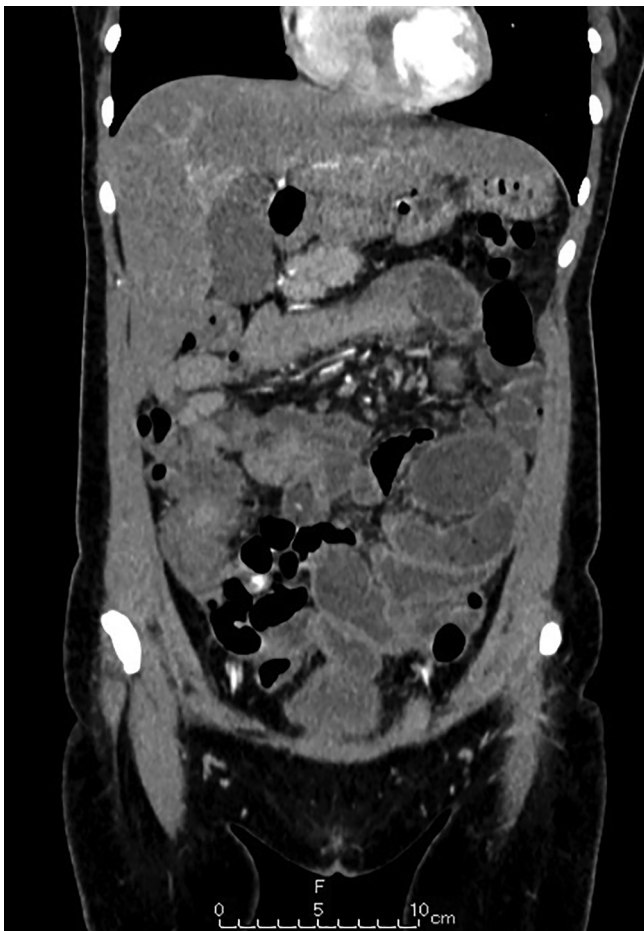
Contrast-enhanced CT, the peritoneum and the omentum is thickened.
